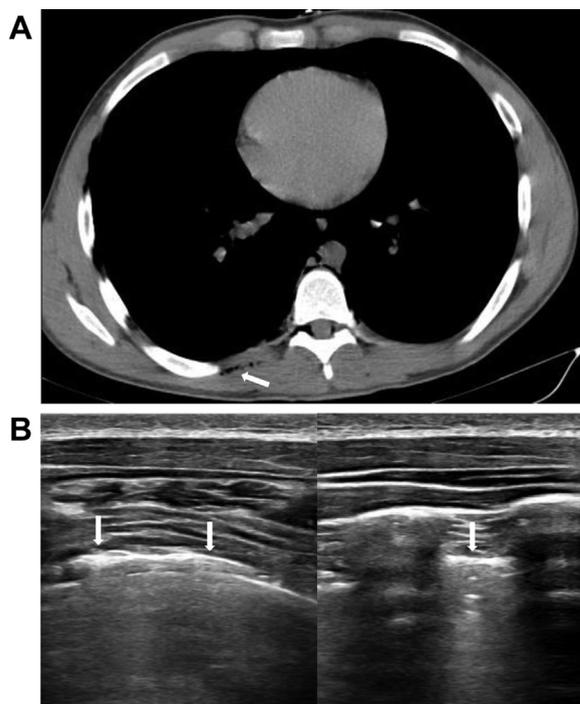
A, On the axial view of chest CT imaging, the air is visible among the intercostal fascial planes (white arrow). B, On sagittal and axial scans of ultrasound, the air interposed among the intercostal fascial planes generates a hyperechoic band (white arrows).
